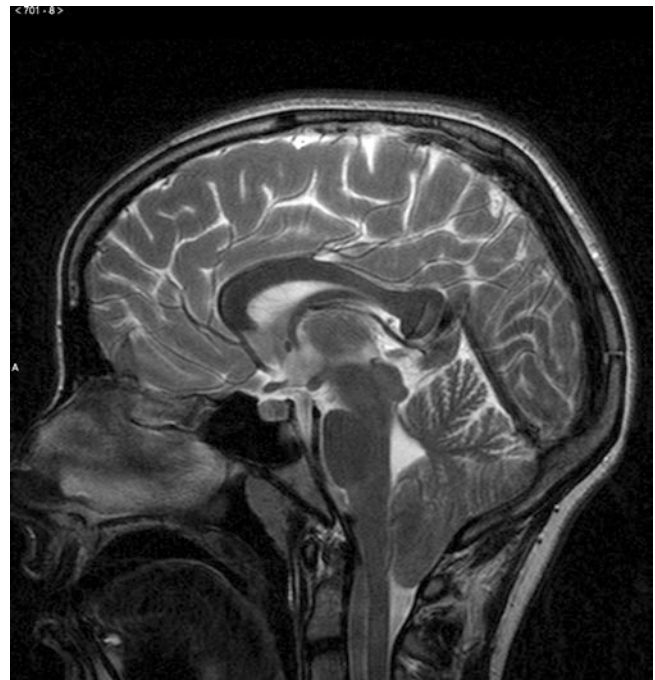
Chiari I malformation. Sagittal T2-weighted MR image shows caudal descent of the cerebellar tonsils below the foramen magnum. The tonsils have a pointed appearance
